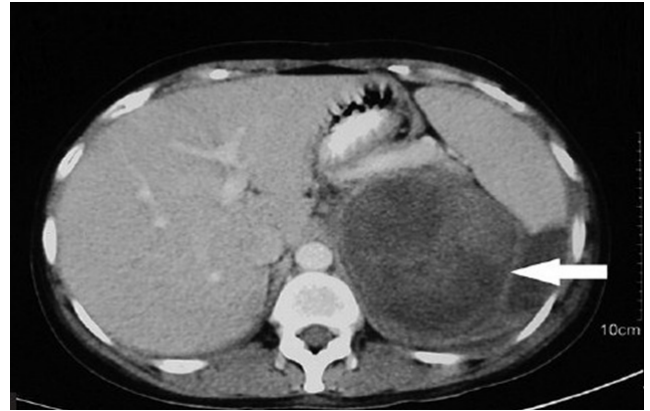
MRI showed a large, 10 x 6x 6 cm, well marginated, heterogenous left adrenal mass abutting the upper pole and posterior margin of left kidney.
